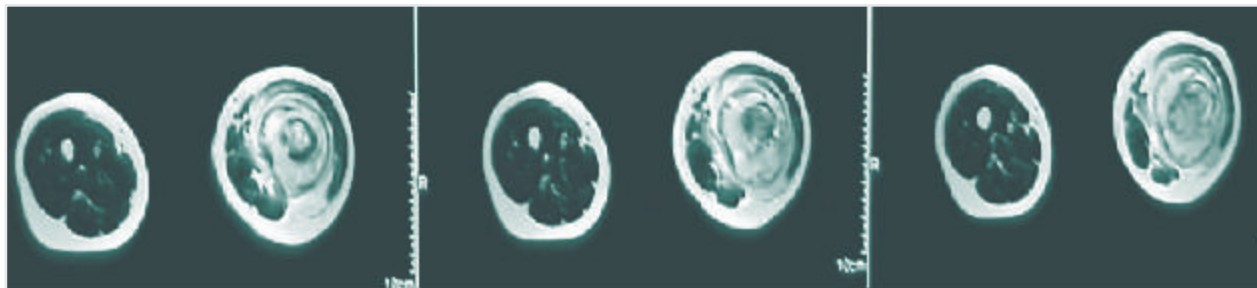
MRI showing metastasis in femur
